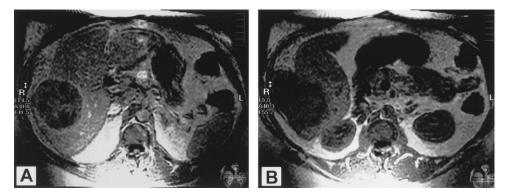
T2-weighted magnetic resonance images (MRI) of the tumor. There is a 3 cm extrahepatic component (A) arising from the inferio-lateral margin of segment VII. The well-circumscript mass measuring $8 \times 8 \times 10$ cm in diameter transgresses the hepatic capsule (B), but lacks invasion of the abdominal wall.
